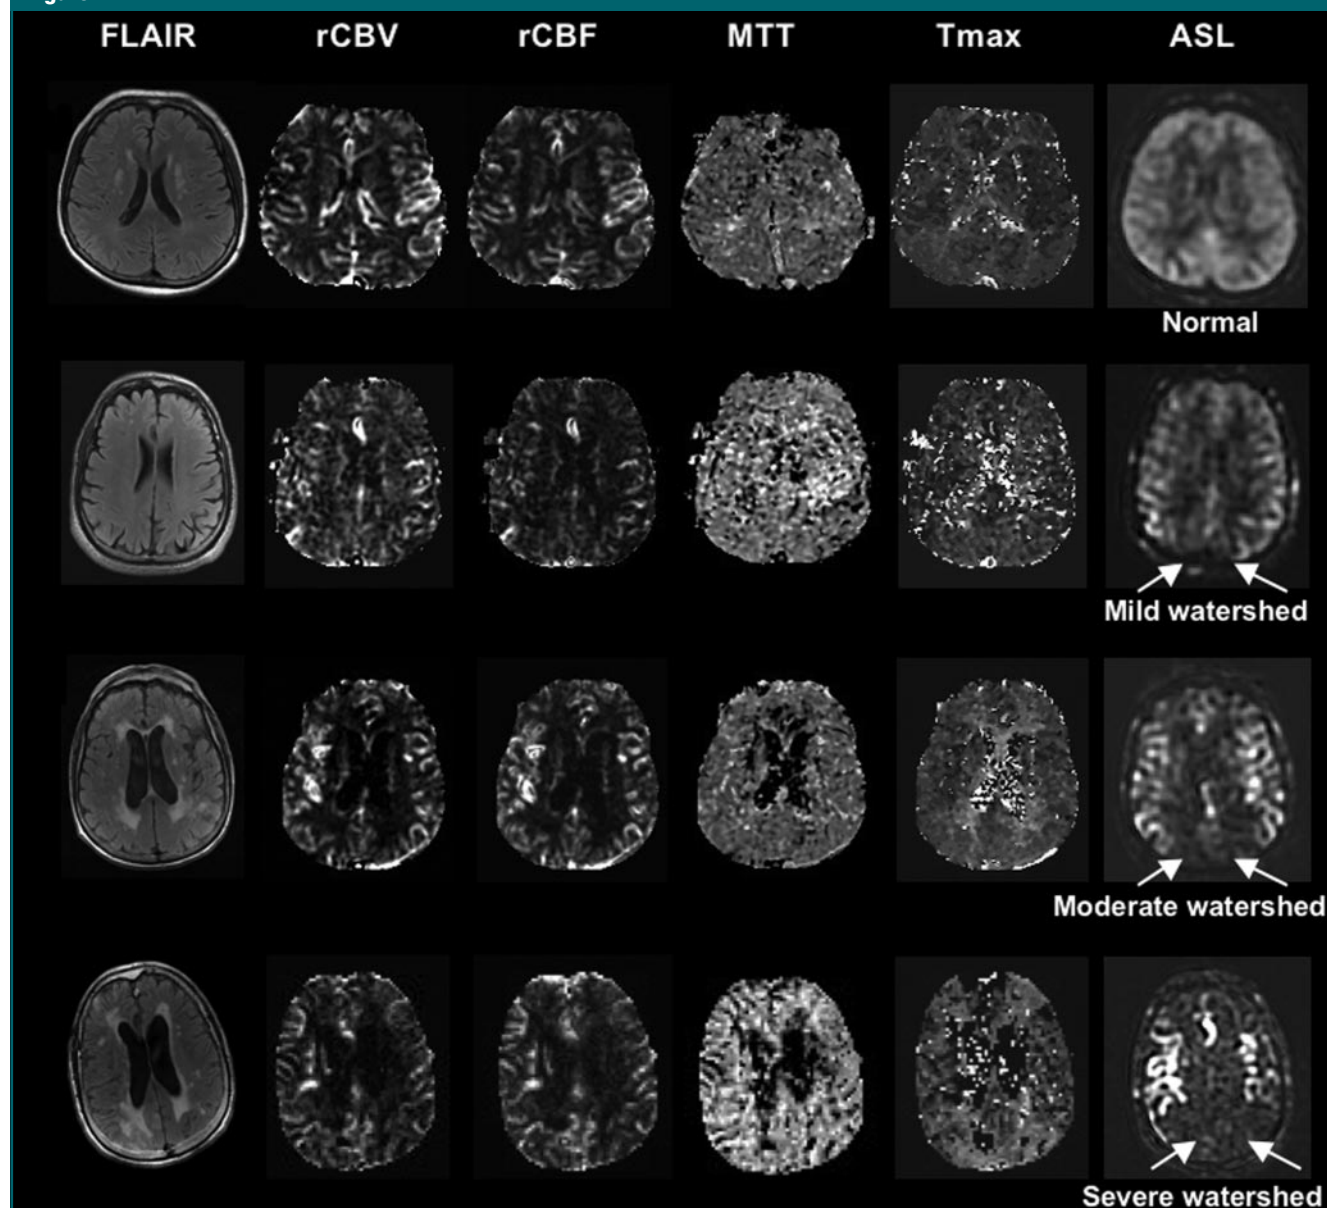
Common ASL imaging findings in four patients (four rows) with normal bolus PW imaging findings. Fluid-attenuated inversion-recovery (FLAIR) (8802/110/2200) relative cerebral blood volume (rCBV), relative CBF (rCBF), mean transit time (MTT), and normalized time to peak of the residue function (Tmax) maps (1225/17, 30, 52) are shown for comparison. Many ASL images show the borderzone sign (ie, watershed, arrows)—that is, signal dropout in the bilateral MCA–anterior cerebral artery and MCA–posterior cerebral artery borderzones, with serpiginous high signal intensity in the surrounding cortex. The severity of this sign ranges from mild to severe. In the severe case, only the proximal segments of the MCA and anterior cerebral artery are visualized, with a complete absence of parenchymal ASL signal.
